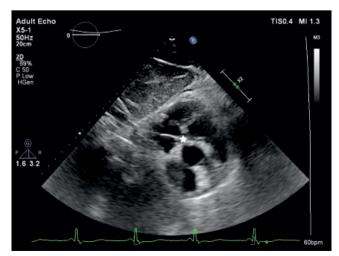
Subcostal short-axis view echocardiography image showing His bundle lead tip fixed on the atrial side of the tricuspid valve (white star).
